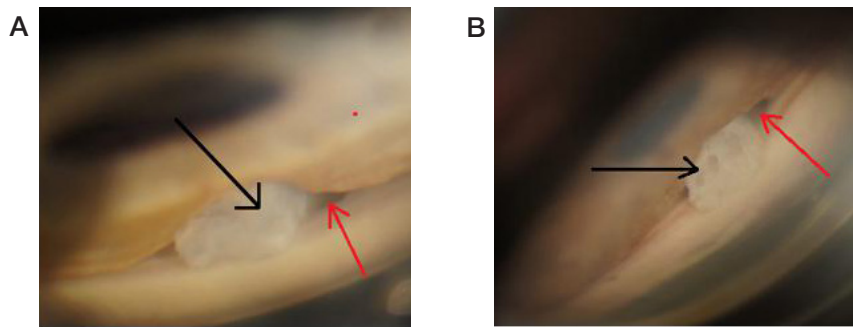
Gonioscopy view of the AC angle. A. 1 month after surgery. B. 12 months after surgery. NACI (black arrow) is in the CT; CC is clearly visible (red arrow)
